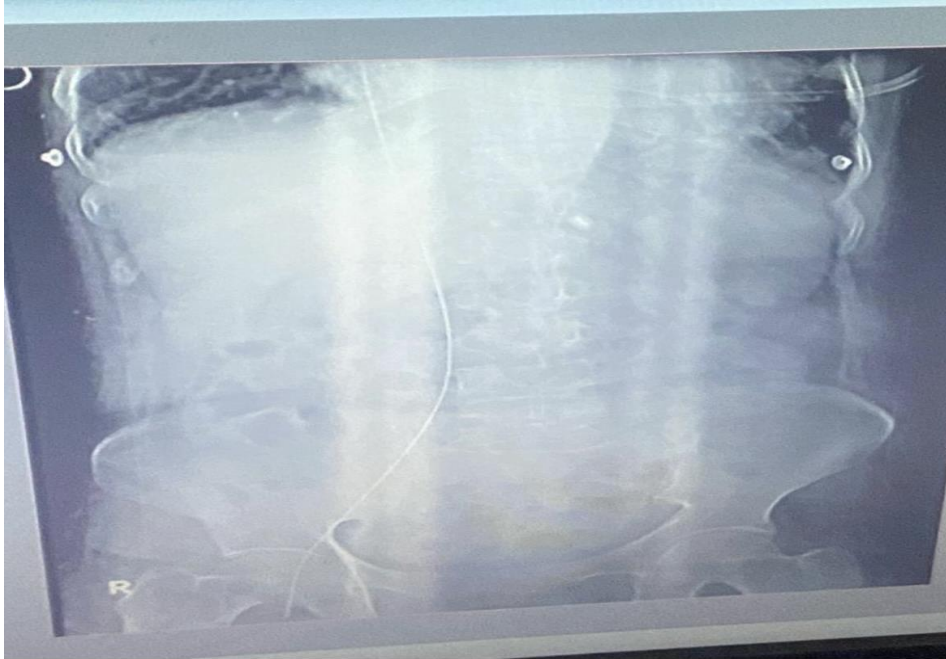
X-ray pelvis/abdomen showing guide wire (arrows) in the right femoral vein upto inferior vena cava
